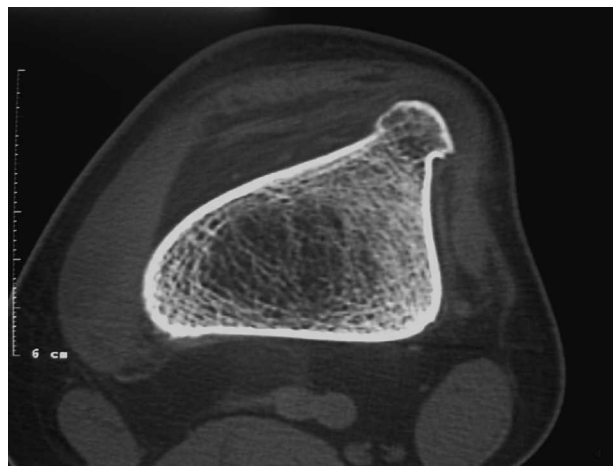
A preoperative axial computed tomography image of an osteochondroma localized in the anterolateral cortex of the distal femur shows the characteristic cortical and medullary continuity between lesion and parent bone.
